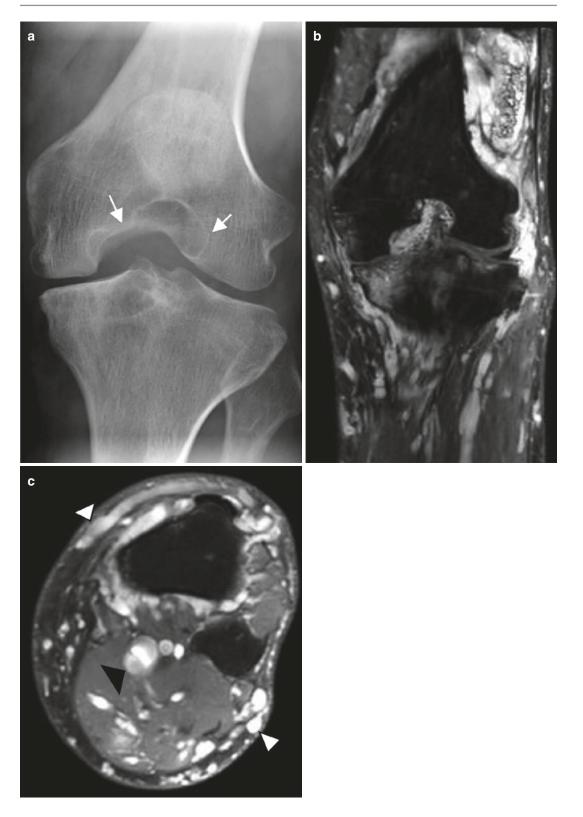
Patient with diffuse and infiltrative venous malformation of the knee. (a) Plain radiograph. (b) Coronal T2-weighted image with fat saturation. (c) Axial T2-weighted image with fat saturation. (a) Plain radiograph shows a widening of intercondylar notch with erosion of the medial femoral condyle. (b, c) MRI
